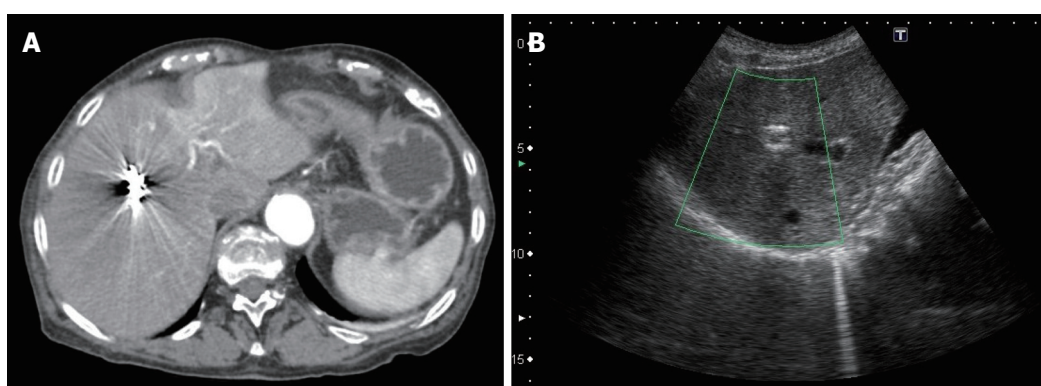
Post embolization imaging. A: Transversal view on the contrast enhanced abdominal computed tomography performed two days after embolization showing that the coils are in place and the absence of blood extravasation; B: Thirty-days control liver ultrasound showing coils in place in the sagittal plane.
